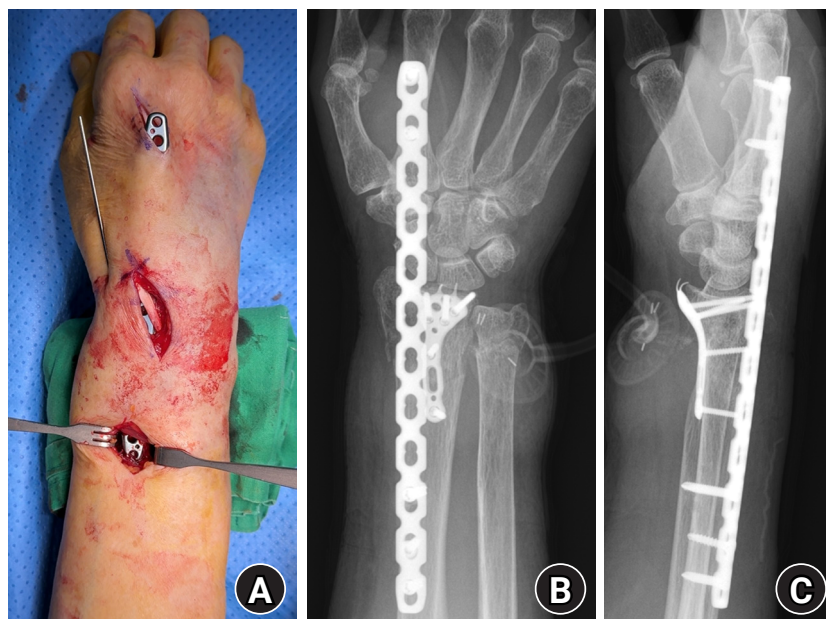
Dorsal spanning plate and volar locking plate fixation. (A) Intraoperative photograph showing the dorsal spanning plate passed beneath the extensor tendons. (B, C) Immediate postoperative posteroanterior and lateral radiographs demonstrating combined dorsal spanning plate and volar plate fixation; the dorsal spanning plate was used to restore length and alignment, and the volar plate was used to restore the articular surface.
